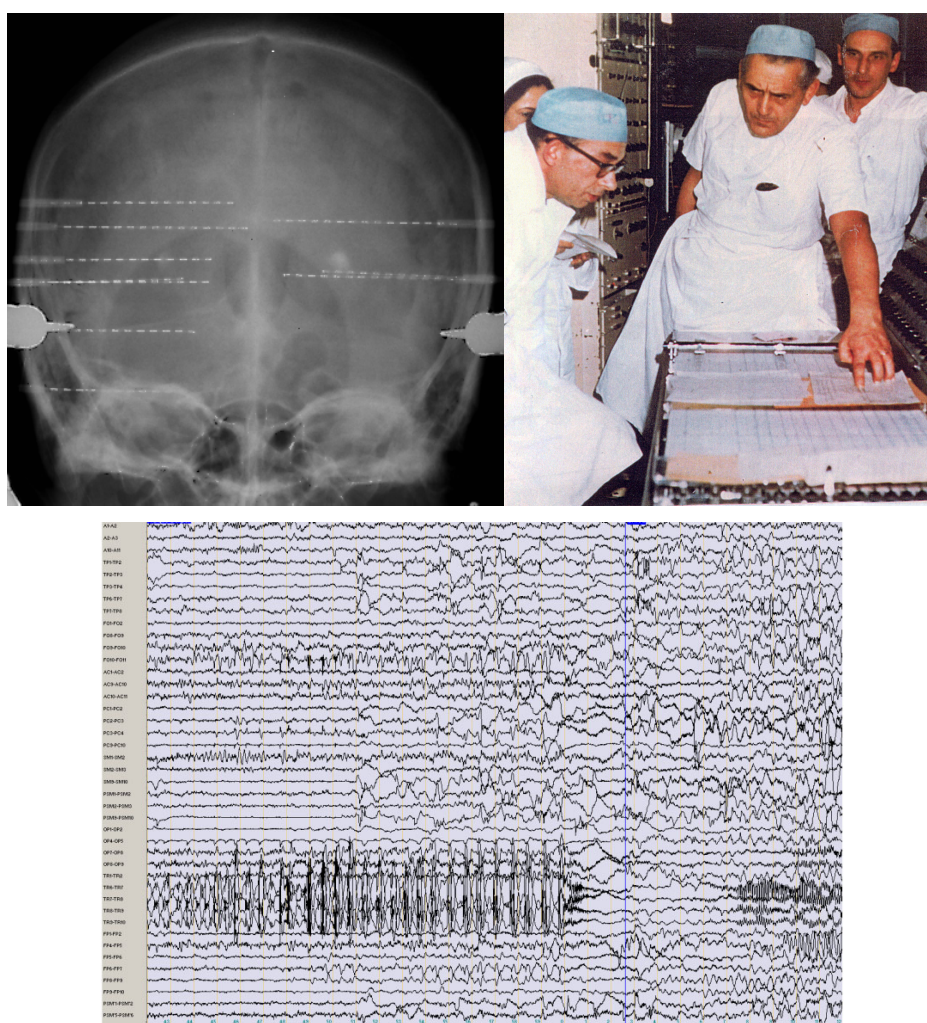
Intracerebral recording using stereoelectroencephalography (SEEG). Top left panel: Skull radiography showing position of SEEG electrodes after implantation. Electrodes are here implanted orthogonally, bilaterally, reaching medial brain structures. The individual recording contacts on each electrode (10 or 15 depending on electrode length) can be seen. The Talairach stereotactic frame, used during implantation, can be seen on the exterior of the skull. Top right panel: Neurophysiologist Jean Bancaud (left) and the neurosurgeon Jean Talairach (centre) interpreting an SEEG trace printed on paper (1970's). Bottom panel: Typical SEEG trace seen on a modern computer screen.
